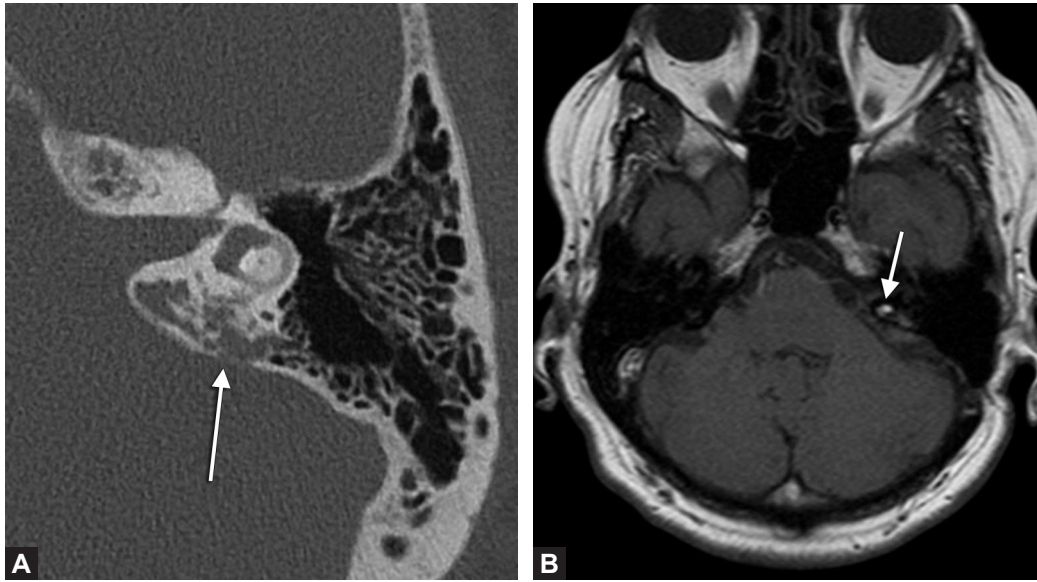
Fenestral otospongiosis. Noncontrast axial CT image of the temporal bone demonstrates lucency (arrow) of the otic capsule in the region of the fissula ante fenestrum.
